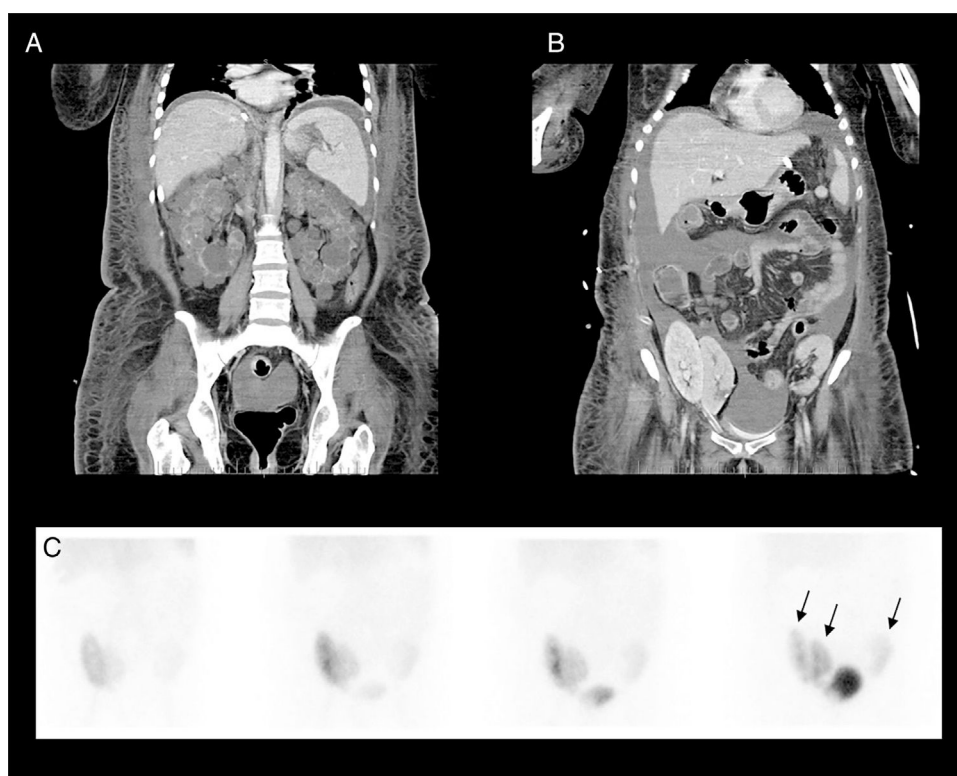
Baseline CT coronal views show polycystic kidneys before the first liver–kidney transplantation (A). Follow-up CT locates the three transplanted kidneys in both sides of the pelvis (B). A renogram study using ^{99m}Tc-MAG₃ was performed identifying different degrees of radiotracer uptake in all three transplanted kidneys (C).
